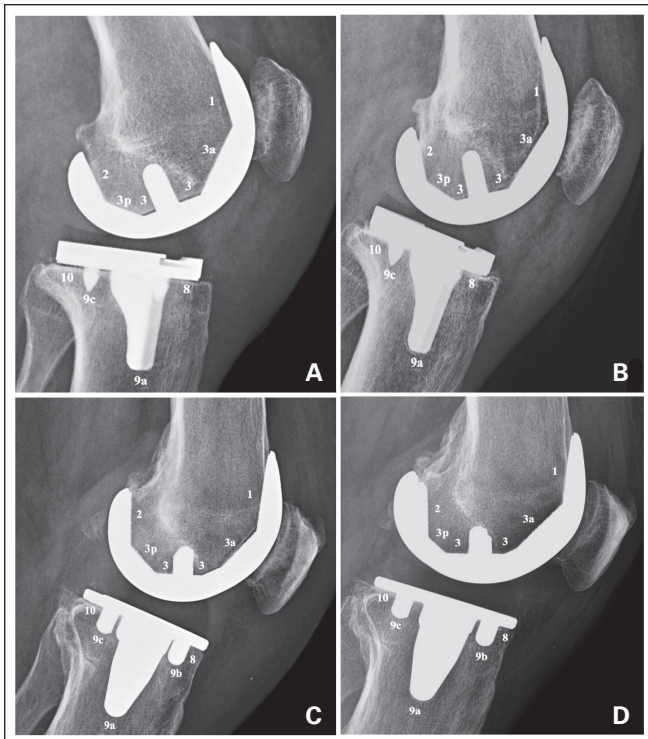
Lateral radiographs at postoperative follow-up 6 weeks and 1 year or more after cementless total knee arthroplasty (TKA). (A) A patient who received the Triathlon system had visible gaps at 6 weeks, which filled by the (B) 1-year follow-up. We observed the same trends at (C) 6-week and (D) 1-year follow-up in a patient who received an Attune TKA. Zones are labelled according to the zonal classification system of modern Knee Society Radiographic Evaluation.³⁰
